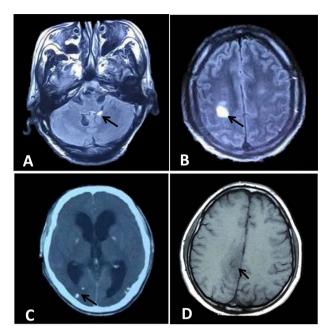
Neuroimaging of a 38-year-old male demonstrating multiple pathological stages. (A) Axial T2WI MRI of infratentorial vesicular stage lesions. The cyst signaled on A appears to be colloidal. Two probable vesicular cysts also appear in this image: in the fourth ventricle lateral recess (right) and in the left peribulbar cistern. (B) Flair sequence MRI of a granular nodular stage lesion on the right centrum semiovale. The cyst appears to be vesicular-colloidal. (C) CT scan of calcified nodular stage lesions on both hemispheres. (D) T1WI MRI of a lesion with characteristics of both the colloidal and nodular/granular stage on the right centrum semiovale.
